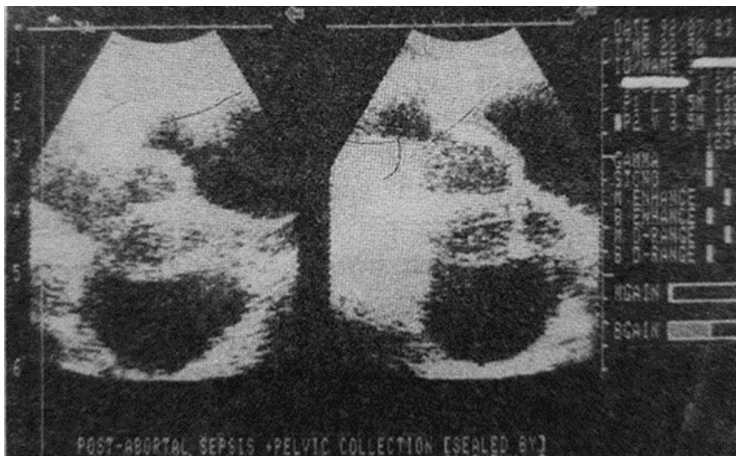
c. Sonograms (Trans. & Long.) showing normal sized, slightly retroverted uterus. There is fluid in the pouch of Douglas and localized fluid over the anterior uterine wall.
